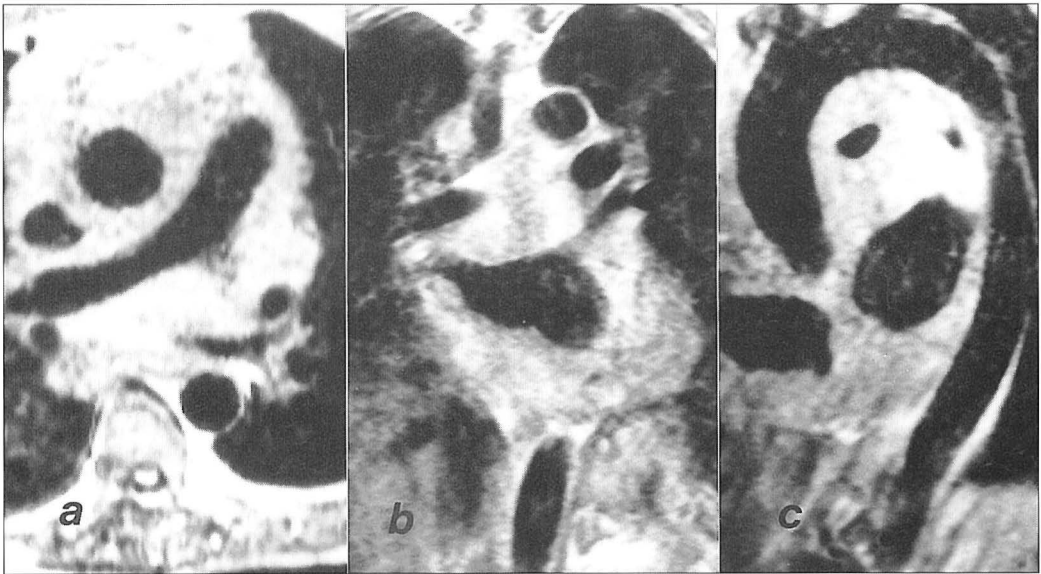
High-grade mediastinal lymphoma diffusely infiltrating the heart. T1-weighted SE images in a - axial, b - coronal, c - LAO plane. The lymphomatous tissue surrounds the ascending aorta, pulmonary arteries and veins. There is a narrowing of the right pulmonary artery and left atrium due to a tumoral thickening of the atrial wall.
